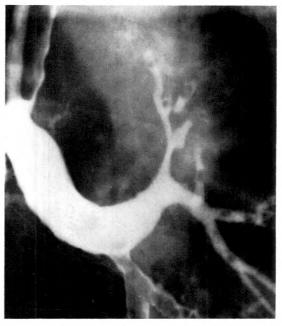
A routine chest roentgenogram demonstrated a mass in the left upper lobe of this asymptomatic 73 year old male. The apical-posterior bronchus of the left upper lobe was selectively catheterized and injection of contrast material revealed a smoothly tapering stenosis with bronchiectatic changes peripherally. The appearance was considered consistent with a postinflammatory stricture. Repeated sputum examinations revealed no tubercle bacilli or abnormal cells. Washings obtained from the segmental bronchus prior to the injection of contrast material also revealed no abnormality. The lesion has not altered in the last year and the patient remains asymptomatic.
